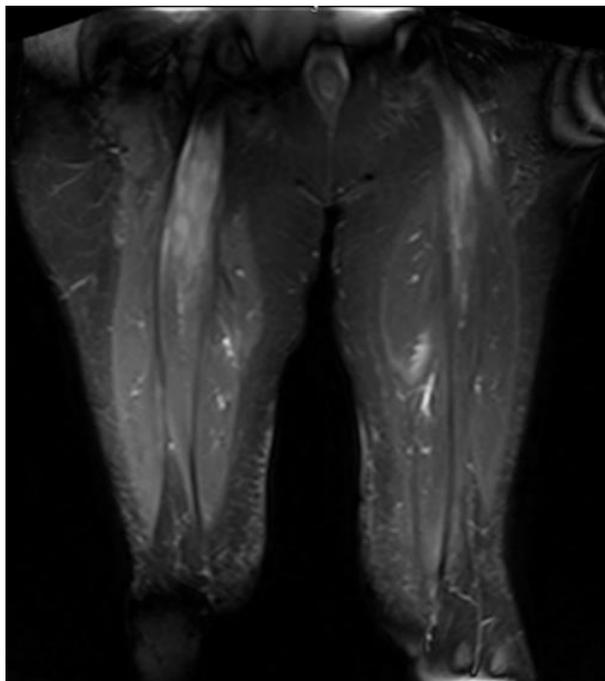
MRI showing abnormal muscle signal intensity.
